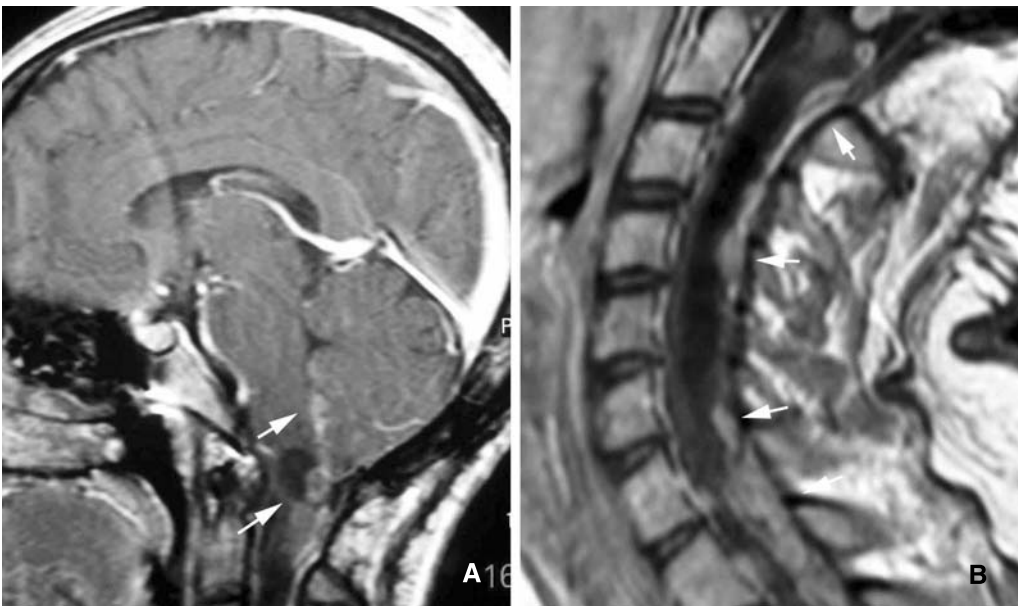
Gadolinium enhanced T1-weighted MRI showing local recurrence in the cerebellar tonsils and obex (A), and tumour seeding along the dorsal surface of cervical and thoracic spine until T3, together with cervical syringomyelia and syringobulbia (B)
